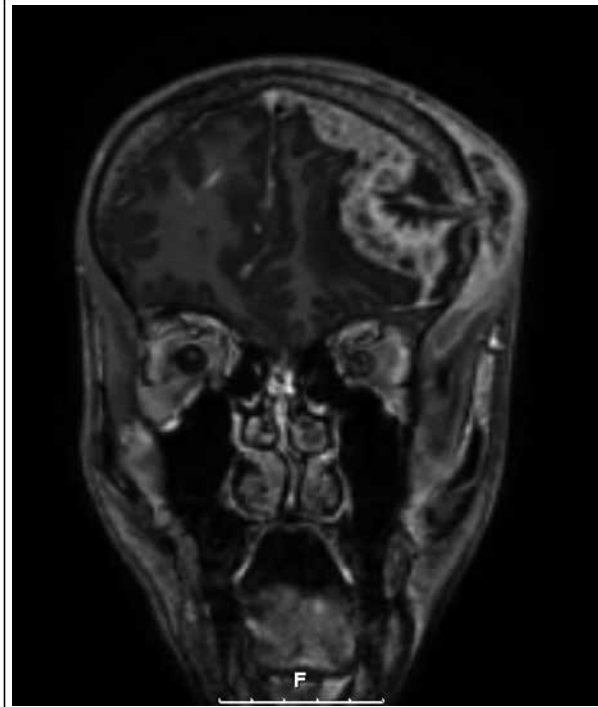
MRI scan (coronal plane) of the cerebrum showing the midline shift to the right caused by the epidural fluid collection
